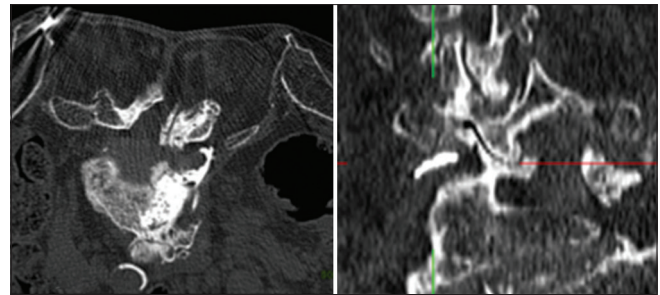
Intraoperative computed tomography (axial/sagittal) showing the cement leakage at the L5 nerve root
